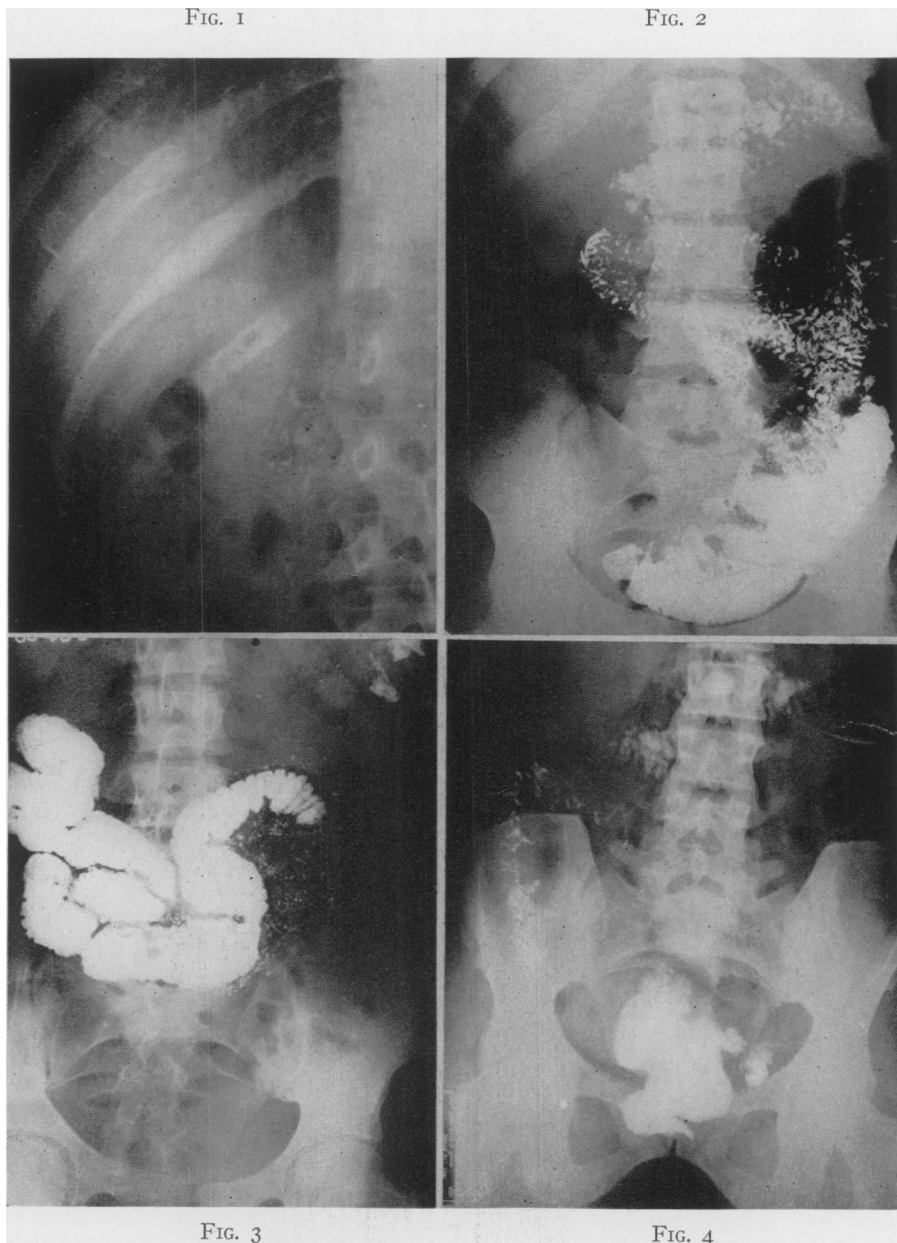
C. F. Unit #672681. Case 2. X-Ray film showing calculi in head of the pancreas.
